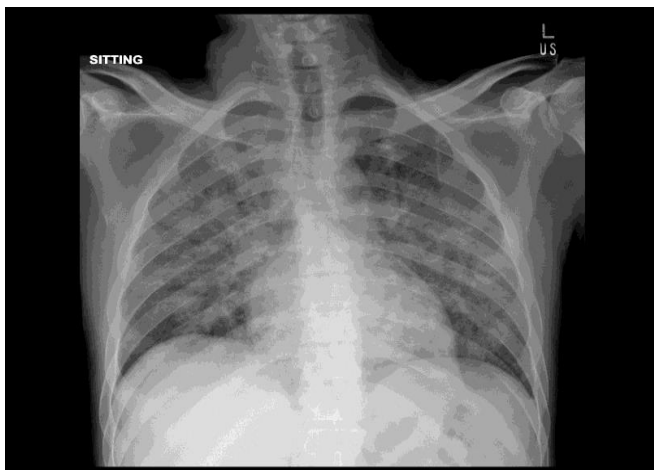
Chest X-ray AP view of HIV positive PTB patient demonstrating bilateral alveolar infiltrates in both lungs.
